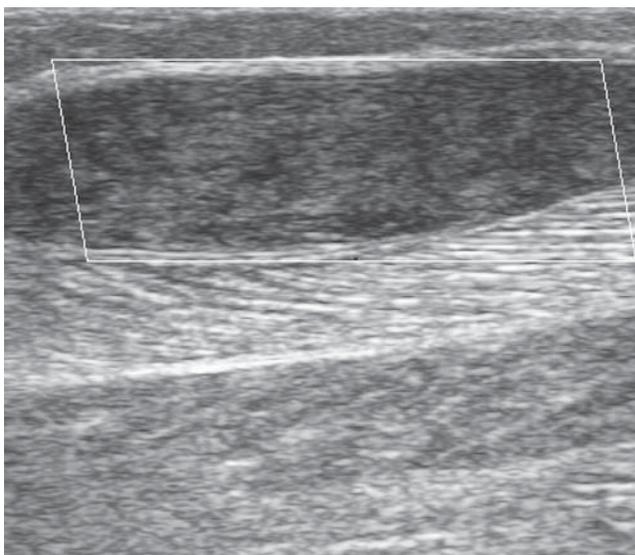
Doppler ultrasound of the calf: complex fluid collection, inhomogeneous, hypoechoic, no Doppler color signal, 25 mm short diameter, more than 100 mm long diameter, probably organized hematoma.
